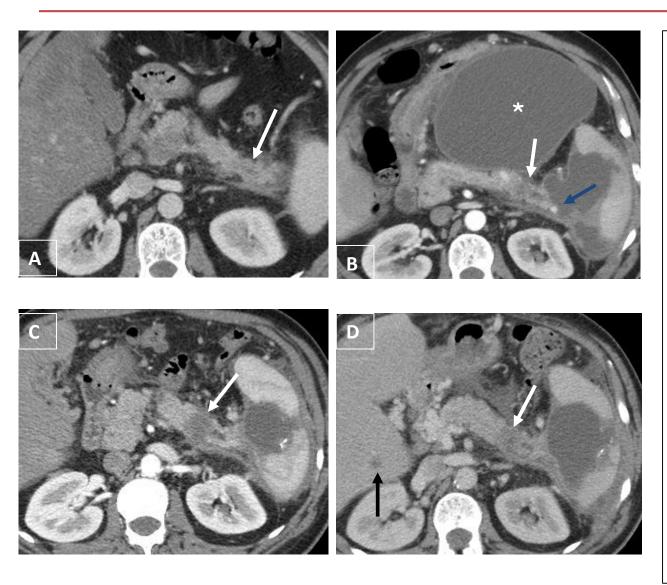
Patient 3. Contrast enhanced CT (A, B). Mild acute left side pancreatitis (A) which on follow-up developed huge pseudocysts (*) and a pseudoaneurysm on splenic artery with hemorrhage (blue arrow, B).
